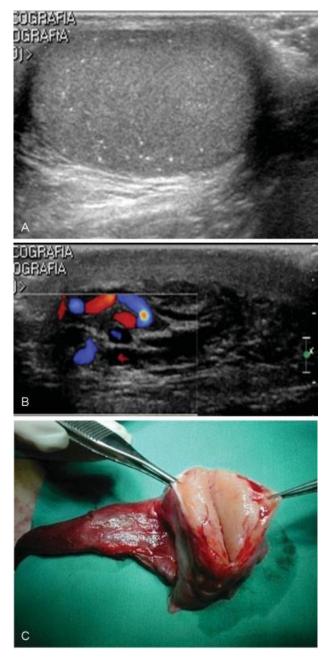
(A) CTM, 2 years before seminoma onset. (B) Same case: Color Doppler. Hypervascularized testicular mass. (C) Same case: Macroscopic view of the testicular seminoma. CTM, classic testicular microlithiasis.
